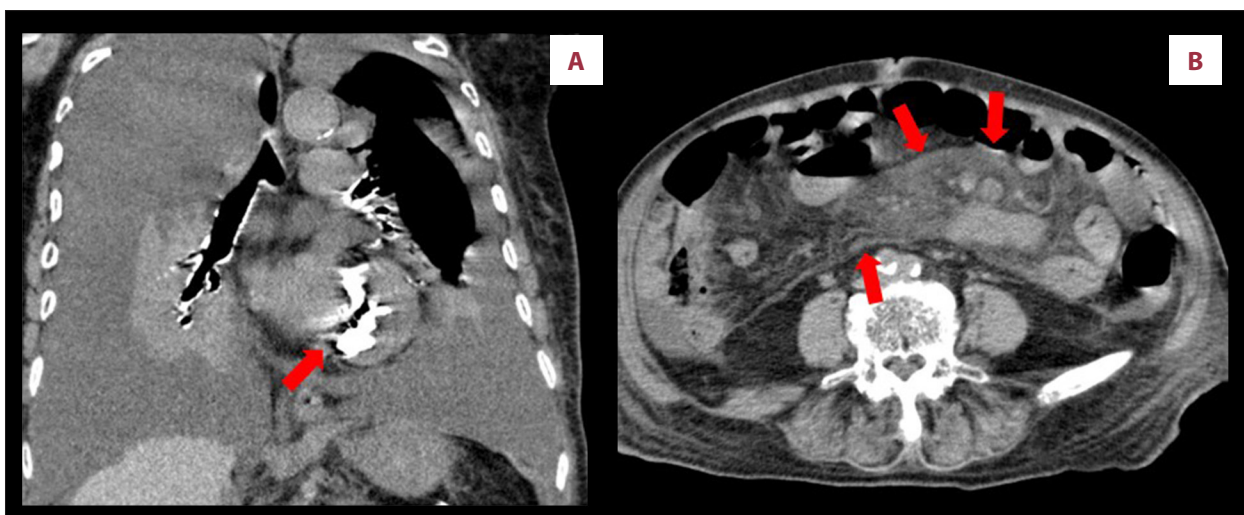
(A) Massive bilateral pleural effusions and mitral annular calcification (arrow) on CT. (B) Misty mesentery with pseudocapsule (arrows) and sub-centimeter lymph nodes on CT.
